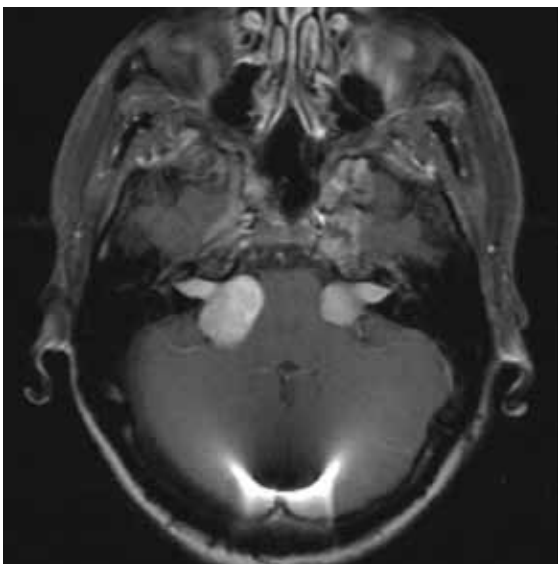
Gadolinium-enhanced axial magnetic resonance images of 30-year-old female showing large bilateral vestibular schwannomas prior to bevacizumab therapy.
